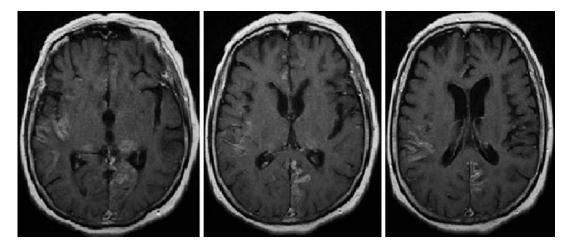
Contrast MRI scan showed leptomeningeal enhancement in the temporal and occipital area in a patient with tuberculous meningitis (TBM)
